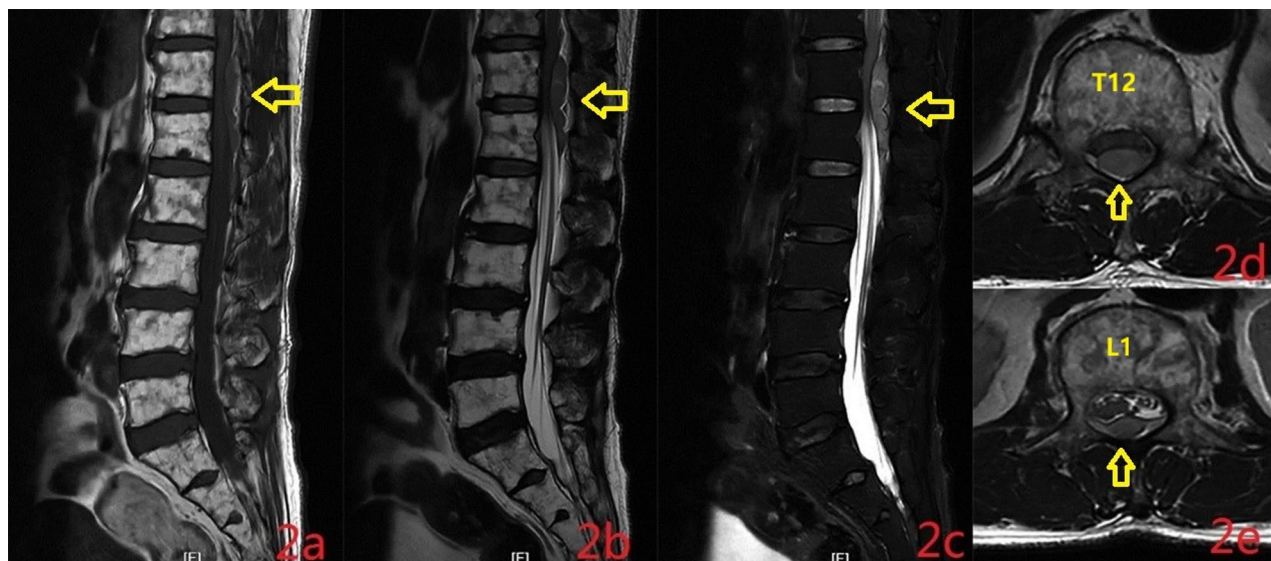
Lumbar magnetic resonance imaging without contrast (on the day of symptom onset), arrow: epidural hematoma occupies the spinal canal and compresses the spinal cord. 2a: A band-like isointense lesion on T1WI was observed within the posterior epidural space at the T11-L1 spinal level. 2b: A band-like hyperintense lesion on T2WI was observed within the posterior epidural space at the T11-L1 spinal level, demonstrating heterogeneous internal signal characteristics. 2c: A band-like hyperintense lesion on T2WI + Fat-Suppressed (T2WI + FS) was observed within the posterior epidural space at the T11-L1 spinal level, demonstrating heterogeneous internal signal characteristics. 2d: On the axial T2WI, at the T12 level within the spinal canal, a space-occupying lesion is observed on the dorsal side. This lesion occupies approximately 60% of the spinal canal's cross-sectional area, resulting in significant compression of the spinal cord. 2e: On the axial T2WI, at the L1 level within the spinal canal, a space-occupying lesion is observed on the dorsal side. This lesion occupies approximately 30% of the spinal canal's cross-sectional area, resulting in compression of the conus medullaris
